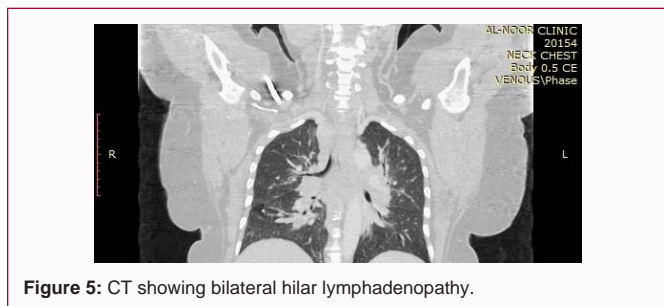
CT showing bilateral hilar lymphadenopathy.
